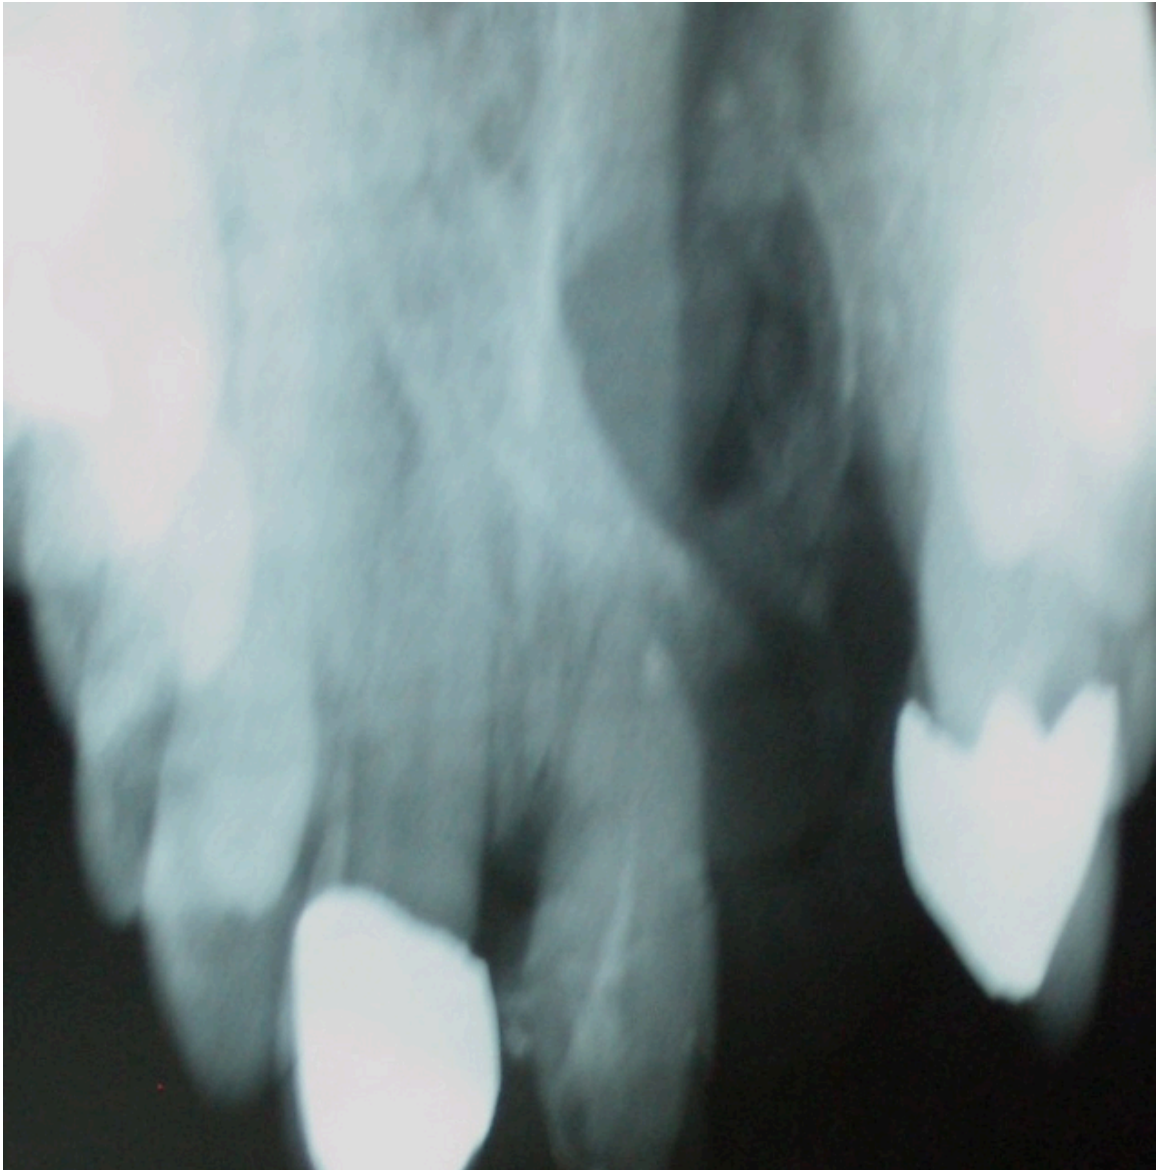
Radiograph of a cleft of the maxillary alveolar bone.
